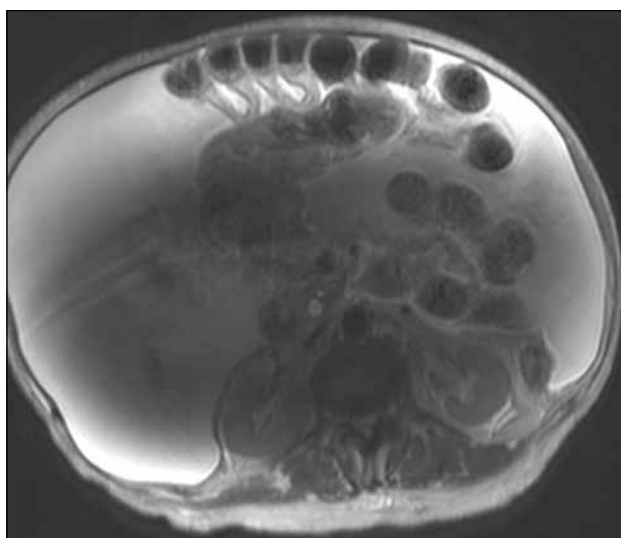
Axial T2-weighted image of the abdomen showing the dielectric effect with signal loss at the centre of the abdomen. Note that this patient has significant ascites that contributes to the dielectric effect.
